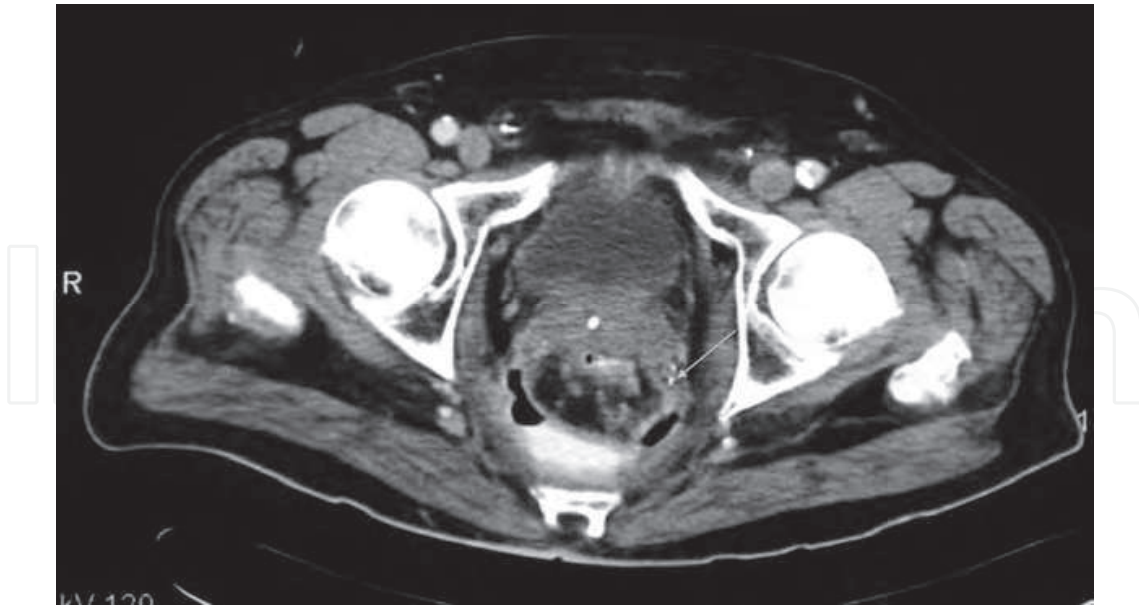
Radiographically proven anastomotic leakage with extraluminal contrast agent (arrow).
